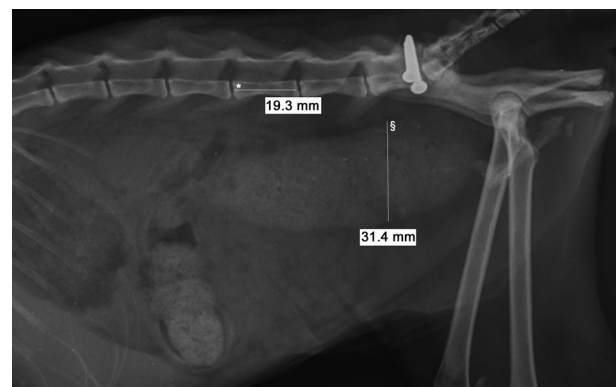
Right lateral abdominal radiograph
